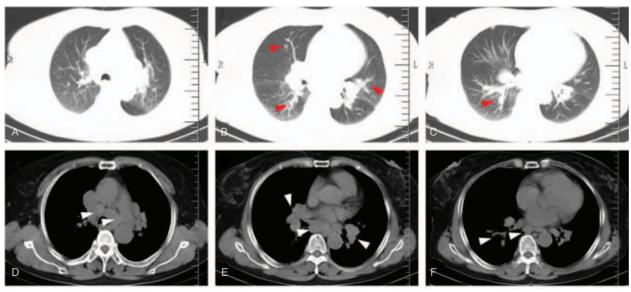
The images of computed tomography scan showed diffuse reticulonodular infiltrates, mediastinal and hilar lymphadenopathy (A-F).
